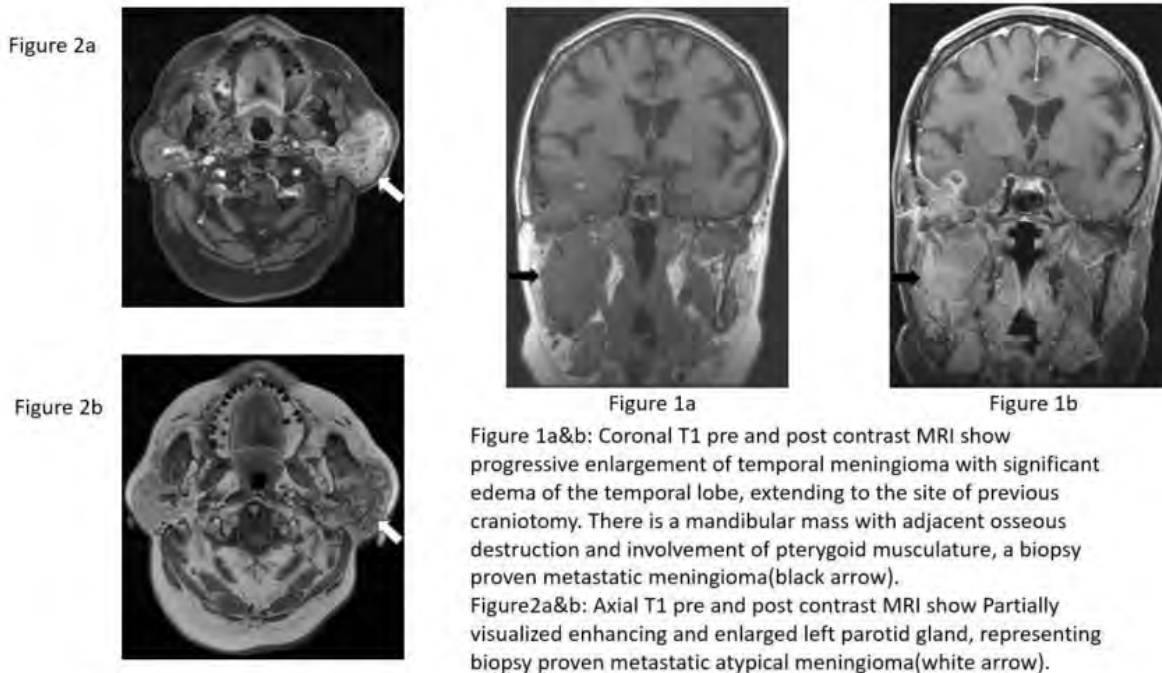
Coronal T1 pre and post contrast MRI show progressive enlargement of temporal meningioma with significant edema of the temporal lobe, extending to the site of previous craniotomy. There is a mandibular mass with adjacent osseous destruction and involvement of pterygoid musculature, a biopsy proven metastatic meningioma(black arrow).
